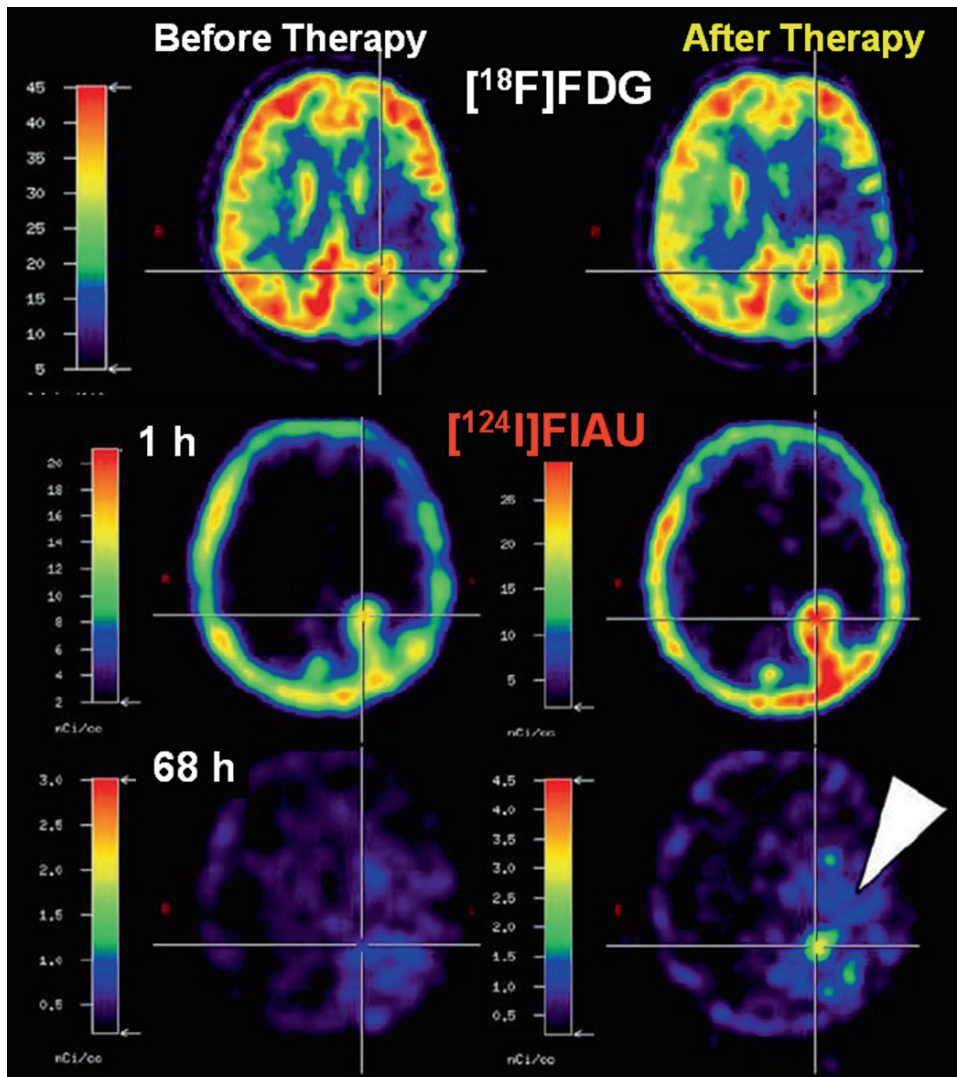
PET imaging studies with FDG and ^{124}I -FIAU to monitor gene therapy (intratumorally infused liposome-plasmid gene therapy vector followed by ganciclovir administration) in a patient with a brain tumor. FDG-PET scan post therapy shows a central
